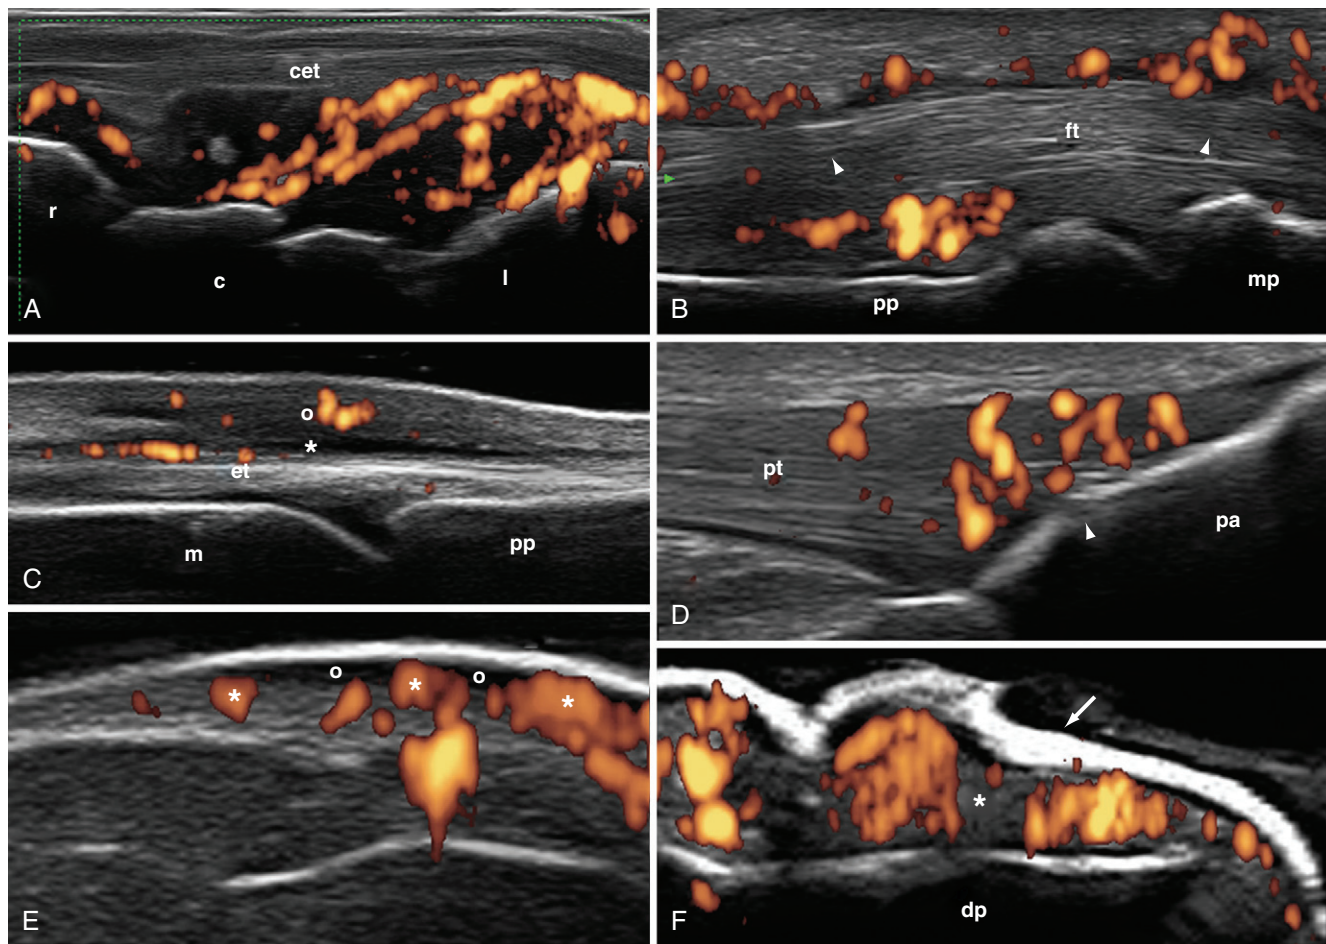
Psoriatic arthritis (ultrasonography). A, Wrist (dorsal longitudinal scan): marked joint cavity widening of both radiocarpal and intercarpal joints with intense power Doppler signal. B, Proximal interphalangeal joint (longitudinal volar scan): chronic tenosynovitis with areas of low tendon echogenicity (arrowheads) and power Doppler signal. C, Metacarpophalangeal joint (dorsal longitudinal scan): peritendinous inflammation characterized by hypoechoic swelling surrounding the extensor digitorum tendon (asterisk) associated with power Doppler signal and subcutaneous edema (circle). D, Distal patellar enthesis (longitudinal anterior scan): thickening of the enthesis associated with intense power Doppler signal and bone erosion (arrowhead). E, Psoriatic plaque: hypoechoic subepidermal thickening (circle) with intense power Doppler signal (asterisk) indicating vasodilatation and angiogenesis. F, Psoriatic onychopathy: loss of the normal trilaminar aspect of the nail plate (arrow), thickening of the nail bed (asterisk), and intense power Doppler signal. c, capitate; cet, common extensor digitorum tendons; dp, distal phalanx; et, common extensor tendon of the finger; ft, flexor finger tendons; l, lunate; m, metacarpal bone; mp, middle phalanx; pa, patella; pp, proximal phalanx; pt, patellar tendon; r, radius.
